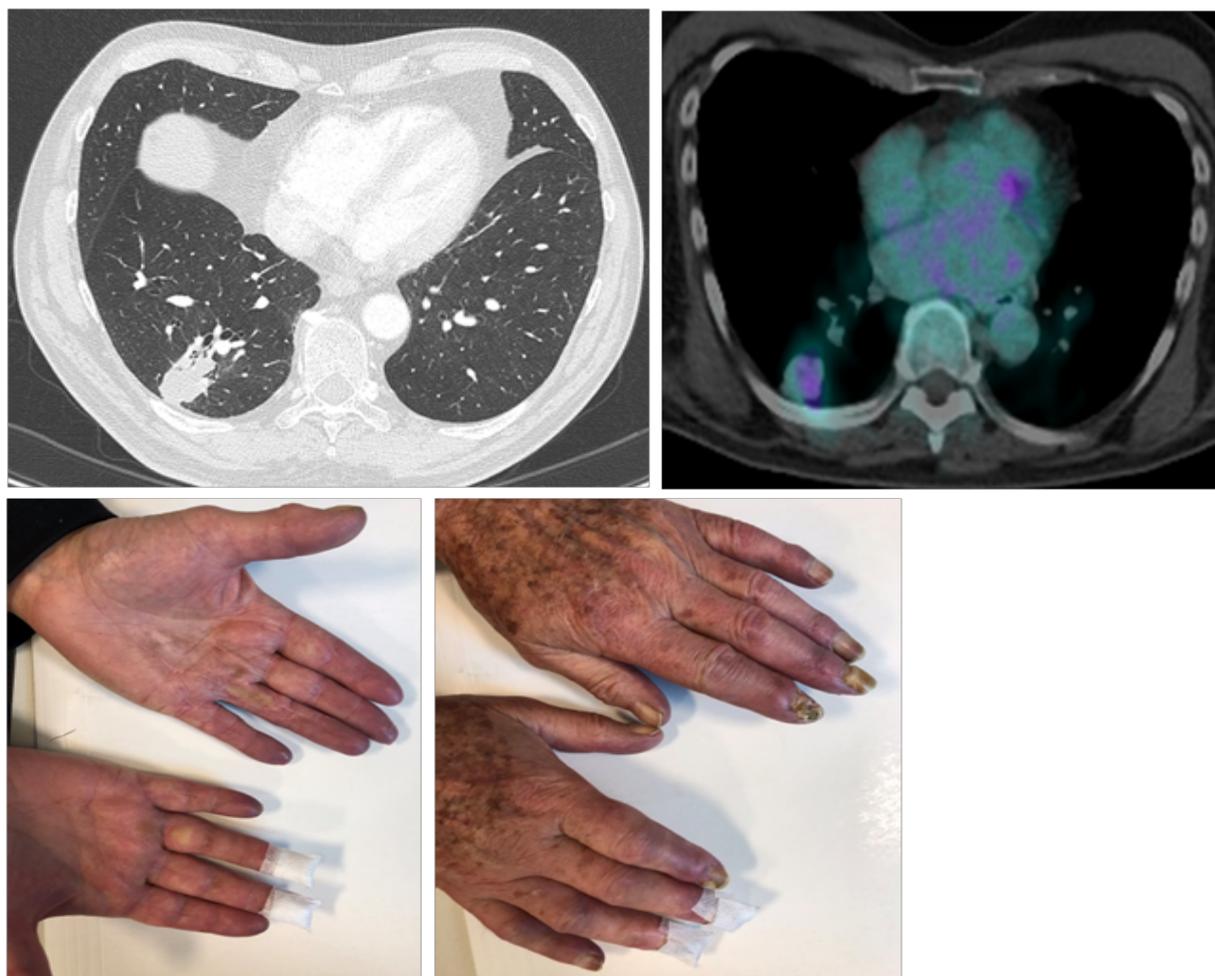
CT June 2018 (6 months after immunotherapy) showing partial response, and FDG PET scan August 2018 showing complete metabolic response. Improving vasculitis clinically.
